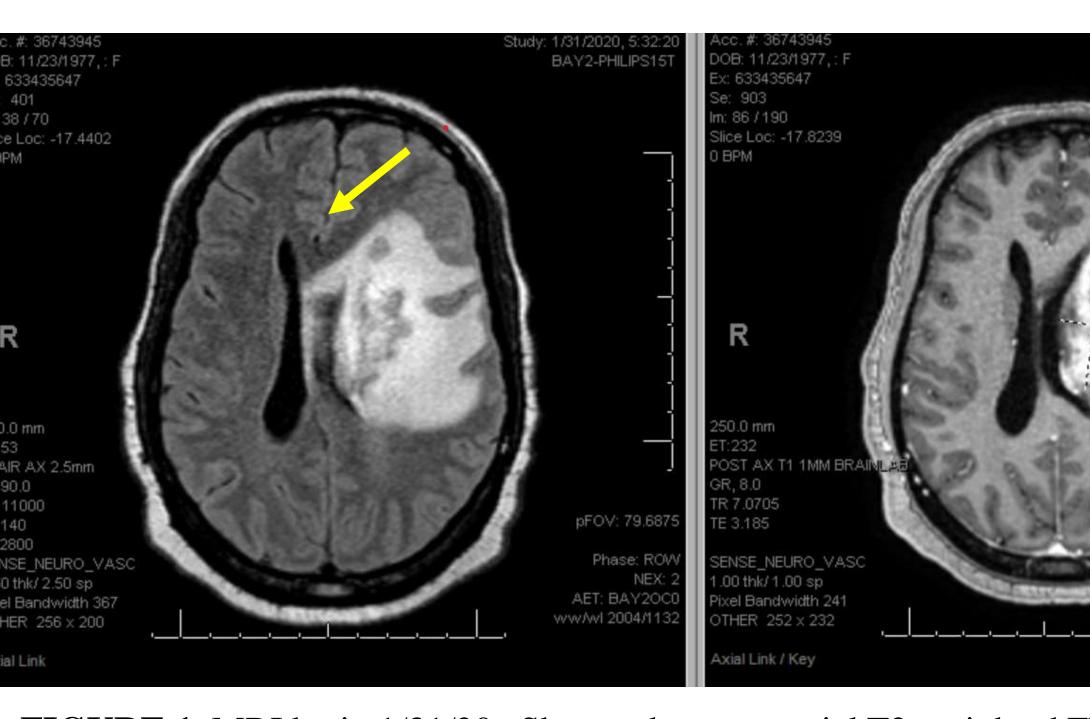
MRI brain 1/31/20. Shown above are axial T2-weighted FLAIR (left) and post-contrast T1-weighted (right) images. Note the extensive vasogenic edema surrounding the diffusion restricted mass and rightward subfalcine herniation (arrow). Findings initially were highly suspicious for lymphoma, metastatic disease, or high-grade astrocytoma.
